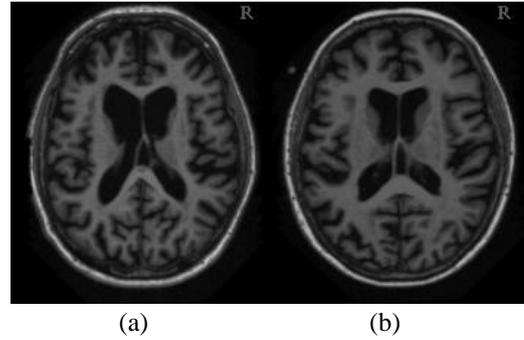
MRI dataset sample of (a) NC and (b) MCI.
